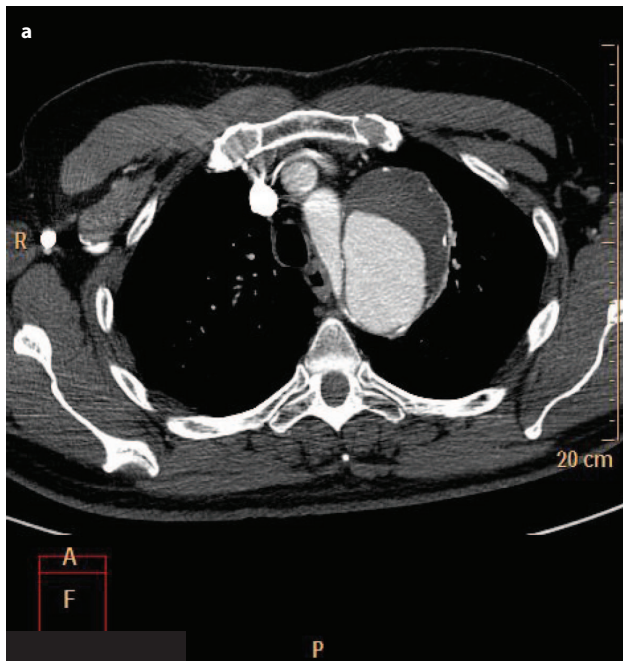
(a) Computed tomography angiography (CTA) at the level of aortic arch (oblique axial view): An aneurysm with peripheral thick thrombus and minor calcifications; (b) CTA of thoracic aorta (oblique coronal view): An oval shaped aneurysm, located distally to the origin of left subclavian artery, connected to the aortic lumen with a narrow neck.
